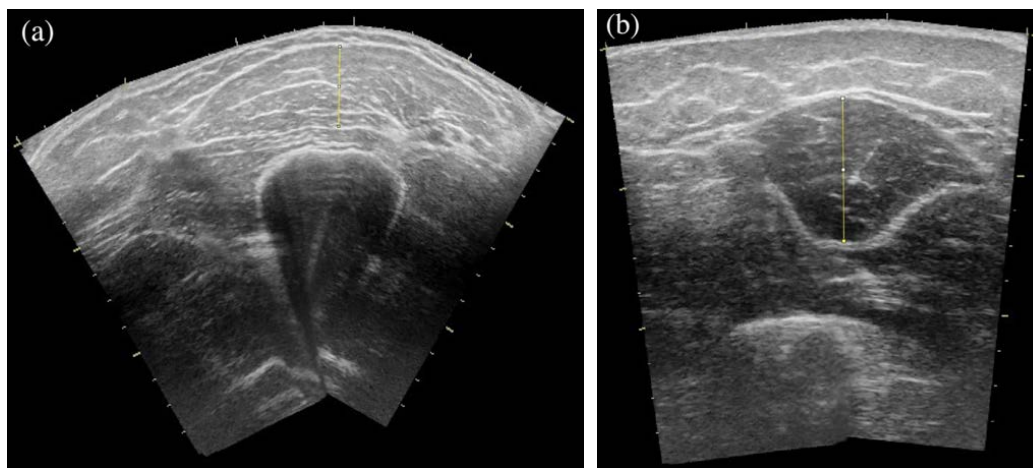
Panoramic ultrasound images of the biceps brachii (a) and long head of the triceps brachii (b) with the straight-line function used for measuring muscle thickness in ImageJ.
